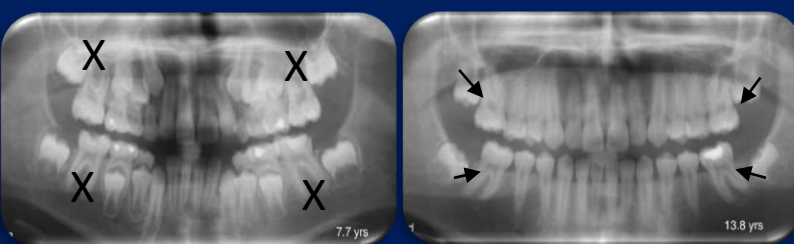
Pre- and post-extraction panoramic radiographs, 6.1 years follow-up.
